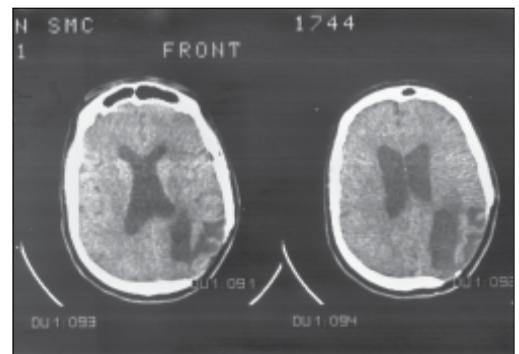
Brain CT from 2001
